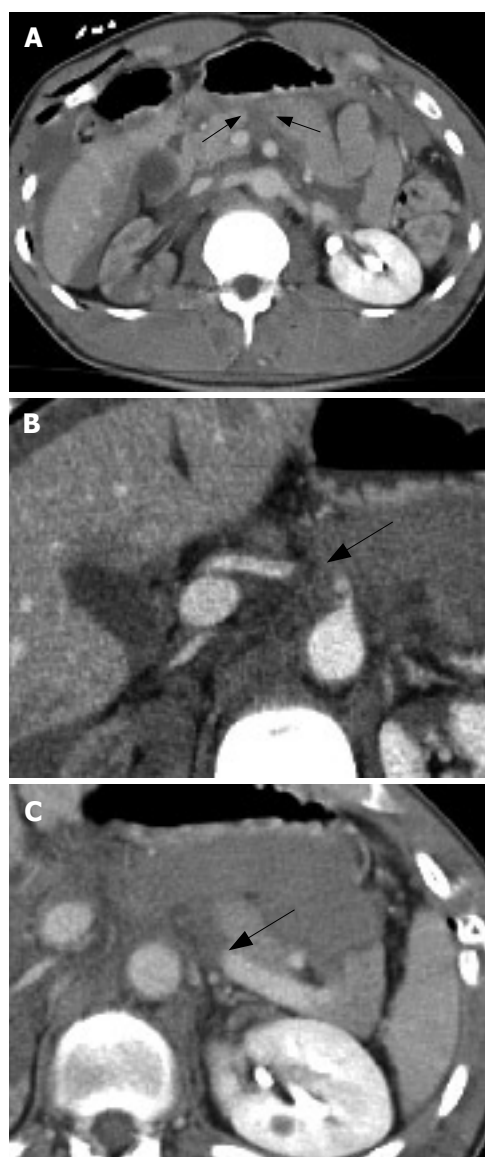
CT scan shows pancreatic transection between the head and body (A), thrombosis of the hepatic artery at its origin from the celiac trunk (B) and rupture/thrombosis of the splenic vein (C).
